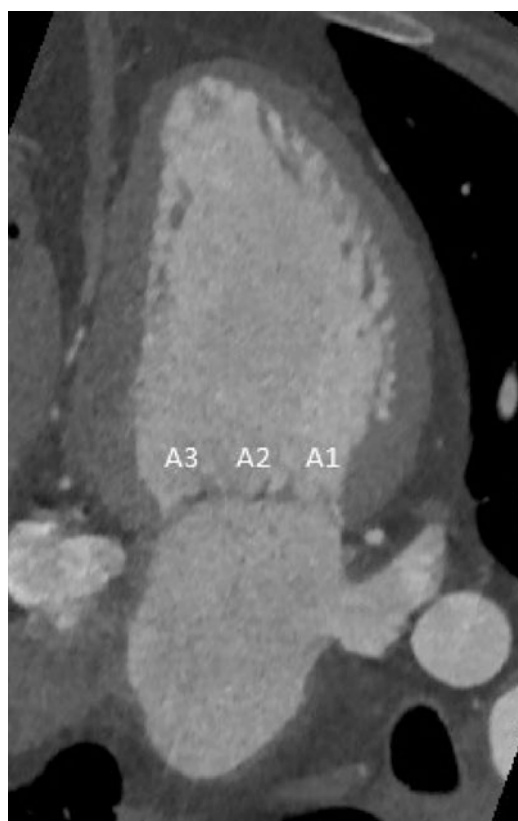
Long axis view on CT showing the cusps starting at lateral A1 under the left atrial appendage to medial A3
